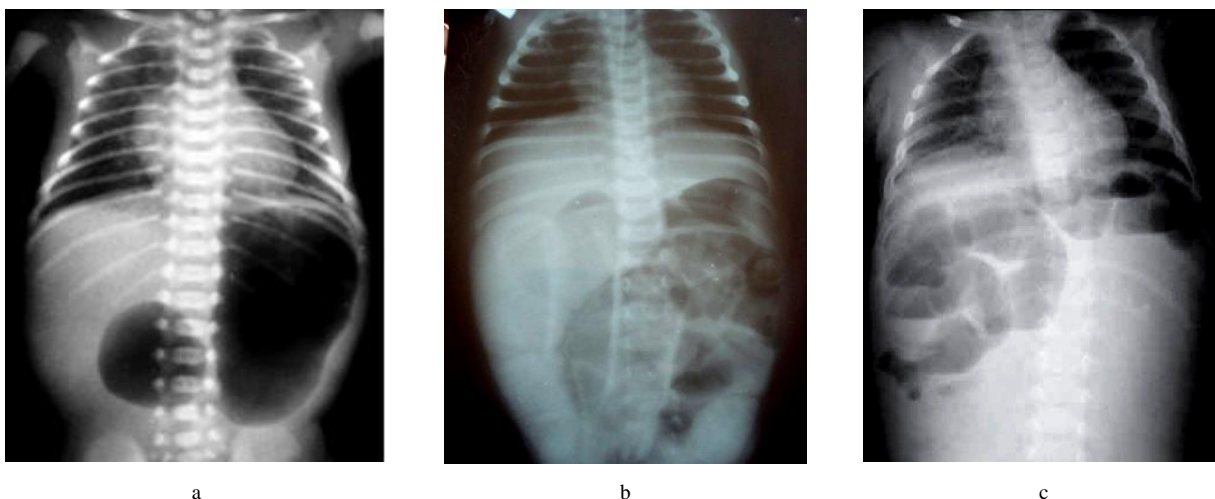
Plain radiography for intestinal obstruction: a) the presence of two fluid levels with high intestinal obstruction; b) accumulation of gas in the dilated colon with low intestinal obstruction; c) the "silent" zone and the initial parts of the small intestine filled with gas indicate malrotation of the midgut
